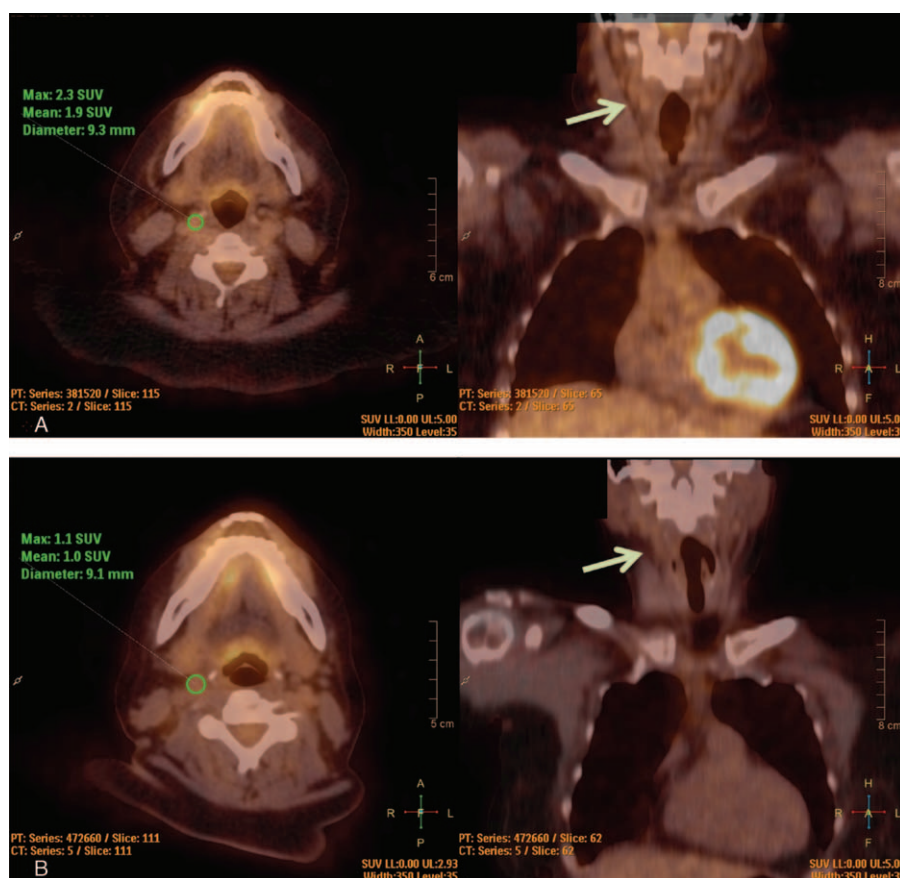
^{18}F -FDG PET/CT image analysis of the carotid arteries (arrows) before and after BaS. ^{18}F -FDG PET/CT images of the neck in transaxial and coronal view (A) before and (B) after BaS. ROIs (green) drawn around the outer border of the vessel wall of the right common carotid artery (SUV_{max} , SUV_{mean} , and diameter of the ROIs) showing higher ^{18}F -FDG uptake values before BaS (SUV_{max} 2.3 vs SUV_{max} 1.1 after BaS). SUV_{max} values were corrected for the blood pool activity in the JVs to derive mean TBR (mean TBR_{max}) values. ^{18}F -FDG = ^{18}F -fluorodeoxyglucose, BaS = bariatric surgery, JV = jugular vein, PET/CT = positron emission tomography/computed tomography, ROI = region of interest, SUV_{max} = maximal standardized uptake value, TBR = target-to-background ratio.
